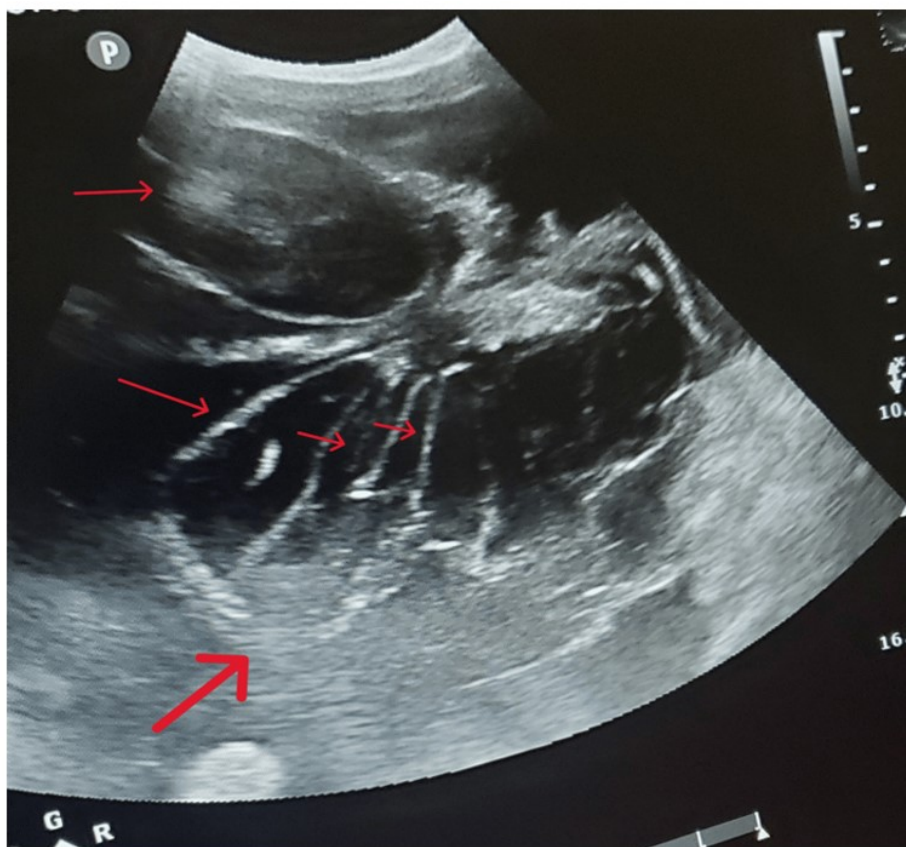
Ultrasound image of the left adnexa showing a multiloculated ovarian mass. The mass is divided into multiple compartments (locules) by numerous thin septa (indicated by red arrows). Internal mixed echoes are present, consistent with mucinous content. These sonographic features are highly suggestive of a mucinous cystadenoma.
